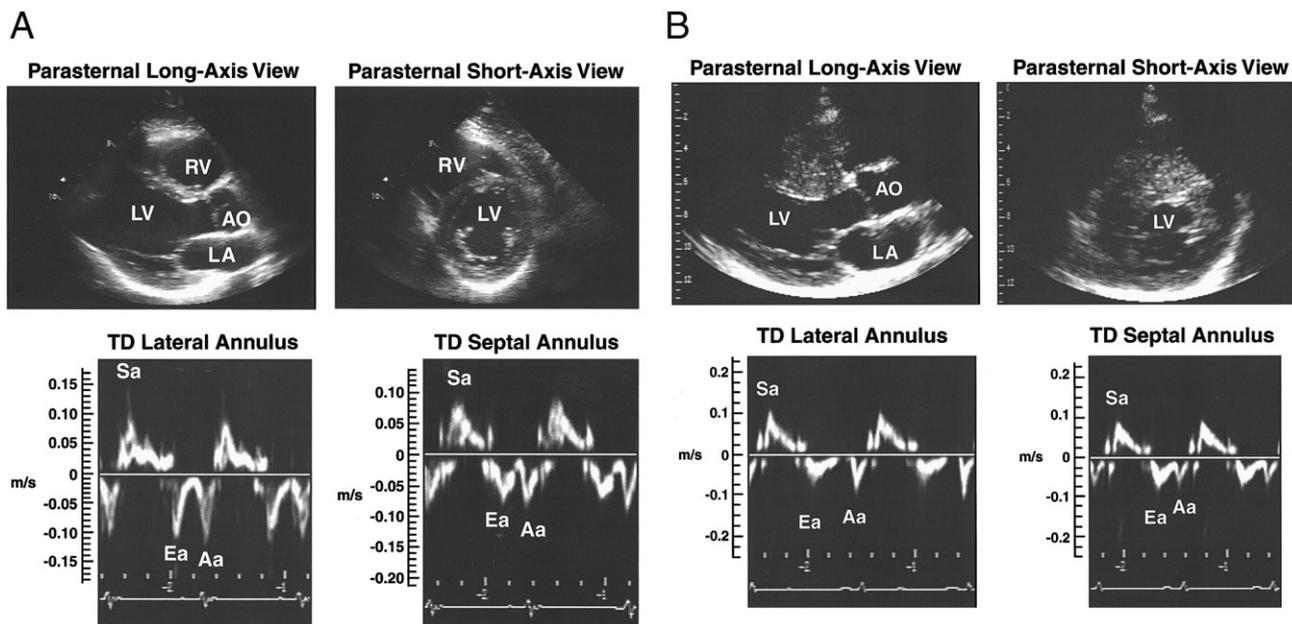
(A) Parasternal long- and short-axis views and tissue Doppler (TD) velocities at lateral and septal side of mitral annulus, from a 20-year-old subject carrying a known mutation for hypertrophic cardiomyopathy. Left ventricular hypertrophy is absent, but systolic (Sa) and early diastolic (Ea) velocities are reduced for age. (B) After 2 years, asymmetric septal hypertrophy developed and TD annular velocities remain reduced. AO = aorta; Aa = late diastolic velocity; LA = left atrium; LV = left ventricle; RV = right ventricle.
